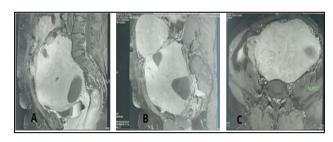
abdominal MRI showing tissue-dense abdominopelvic masses in hypersignal with areas of necrosis; (A) cross-section (B and C) sagittal section.
